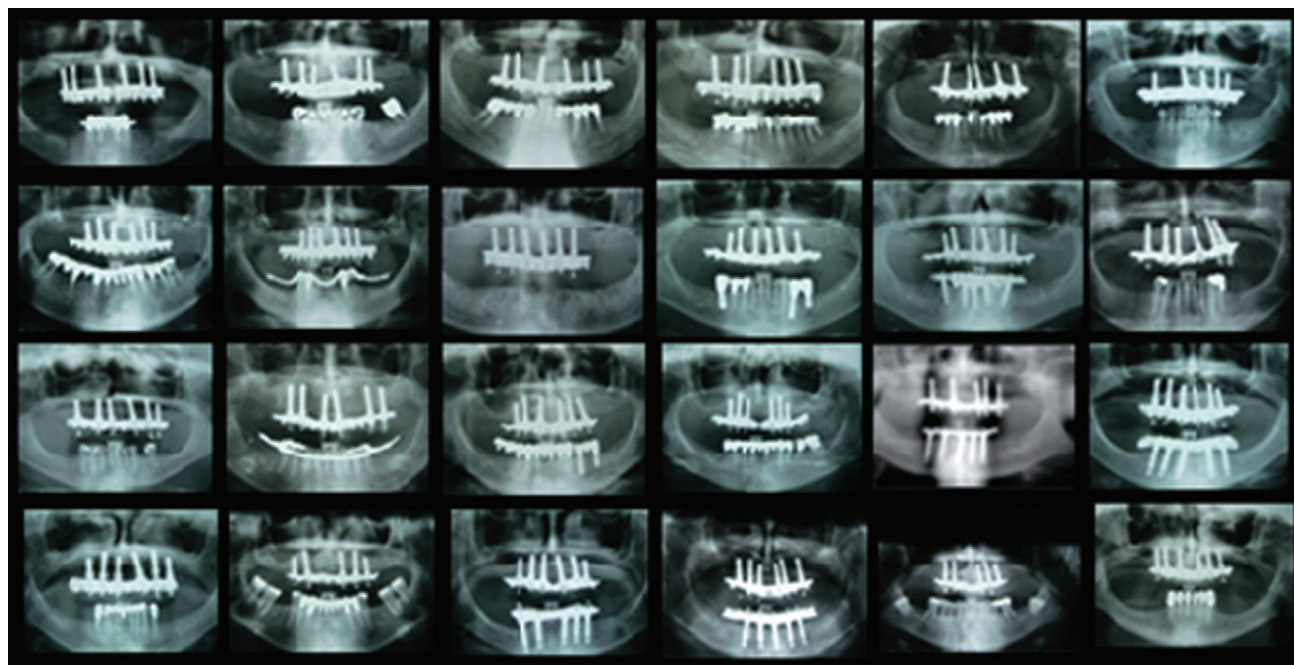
Panoramic radiographs of implant-supported, screw-retained full-arch maxillary prostheses in all 24 patients at time of loading.
